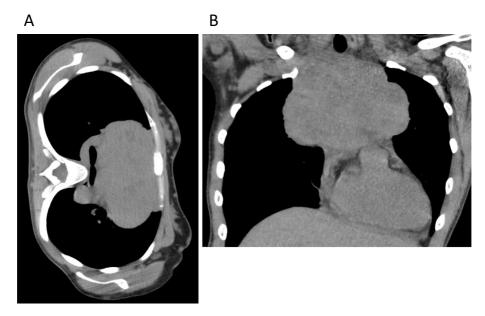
Chest computed tomography (A: sagittal section, B: coronal section) demonstrated a bulky mass in the anterior mediastinum measuring 11.0×5.2×8.7 cm compressing the bilateral main bronchi.
